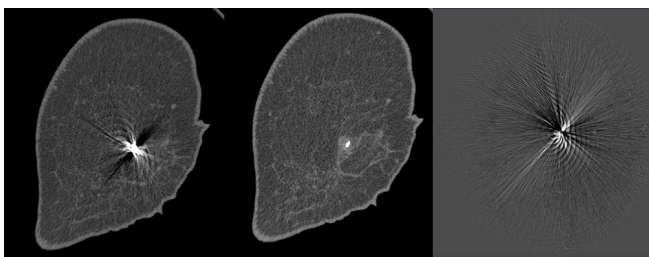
Breast-CT images of a patient after pre-operative implantation of a magnetic marker in a tumor before and after application of the MAR algorithm (no iv-contrast administered). The subtraction of these two images only shows the removed artifact.
